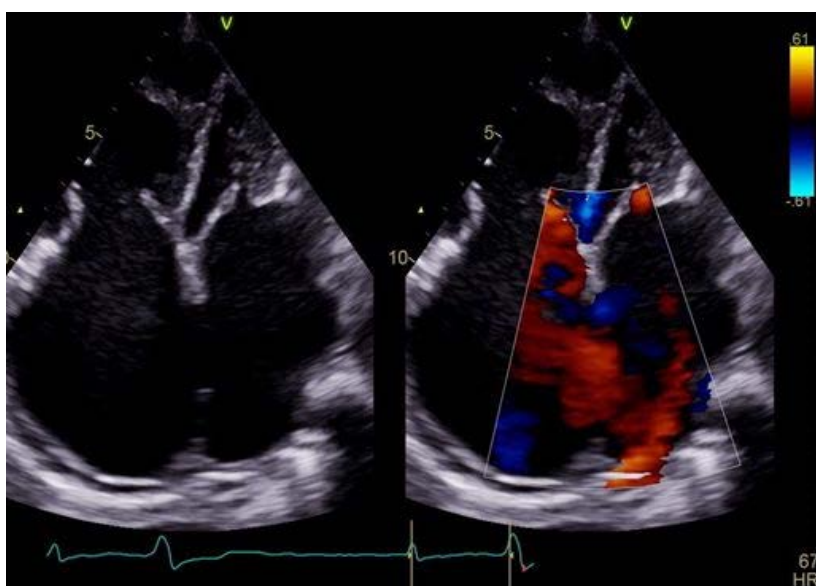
Apical Four Chamber Echocardiogram showing Dilated Right Heart Chambers with Atrial Septal Defect
